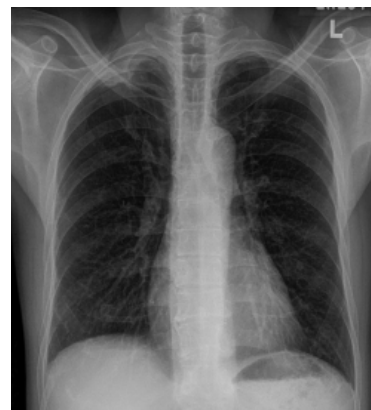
Posterior-anterior chest radiograph post-therapy.
